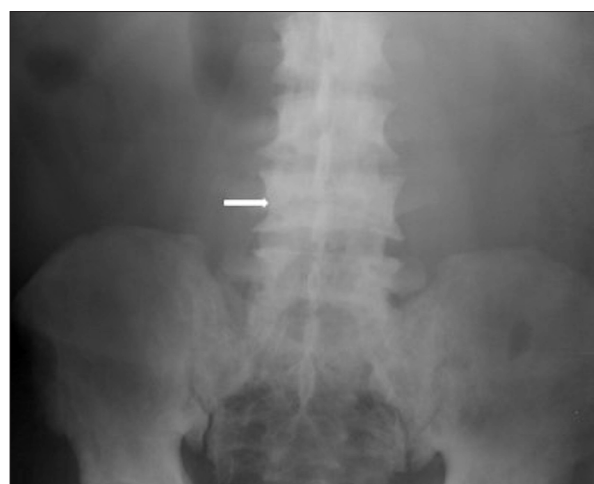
X-radiograph of the lumbar spine in a 74-year-old man with Paget disease and rheumatoid arthritis. X-radiograph of the lumbar spine shows sclerosis of the vertebral bodies with a 'picture frame' appearance (arrow). Diffuse mild sclerosis is present in the pelvic bones.
